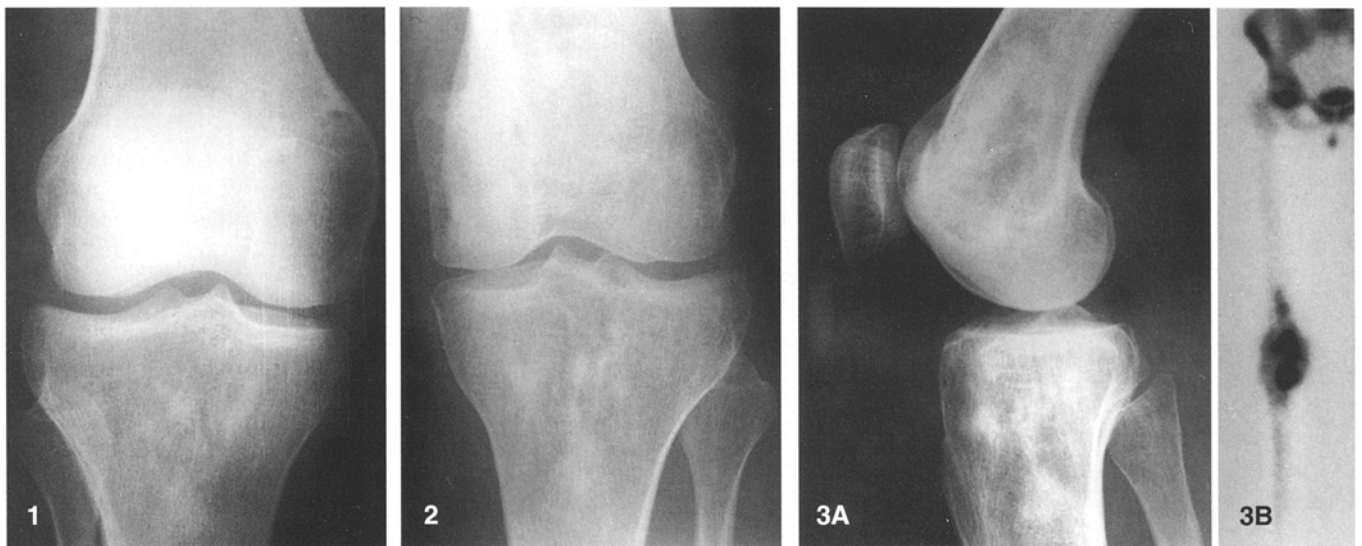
Anteroposterior radiograph of the distal part of the femur and the proximal tibia in 1983 shows the osteolytic lesion in the medial femoral condyle before surgery and an osteolytic area in the proximal tibia with some sclerotic features
